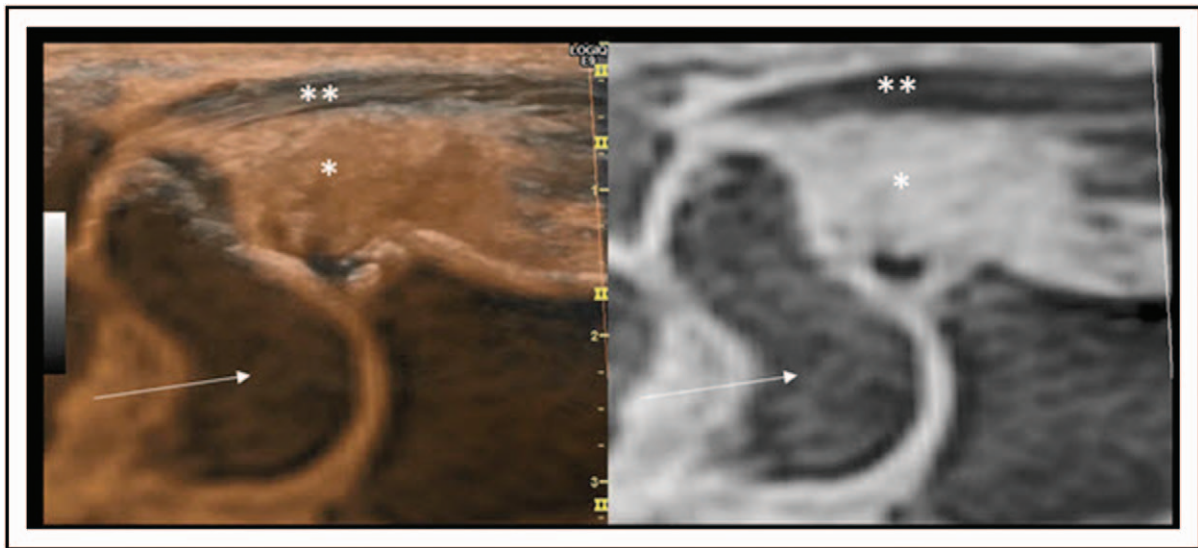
Image fusion of musculoskeletal ultrasonography (MSUS) and MRI. MSUS-MRI overlay (left) and MRI (right) image in sagittal plane of the wrist of a rheumatoid arthritis patient. The flexor carpi radialis tendon with tenosynovitis. *Synovitis in the palmar radial part of the wrist. The scaphoid was used as bony landmark for the image fusion (white arrows).
